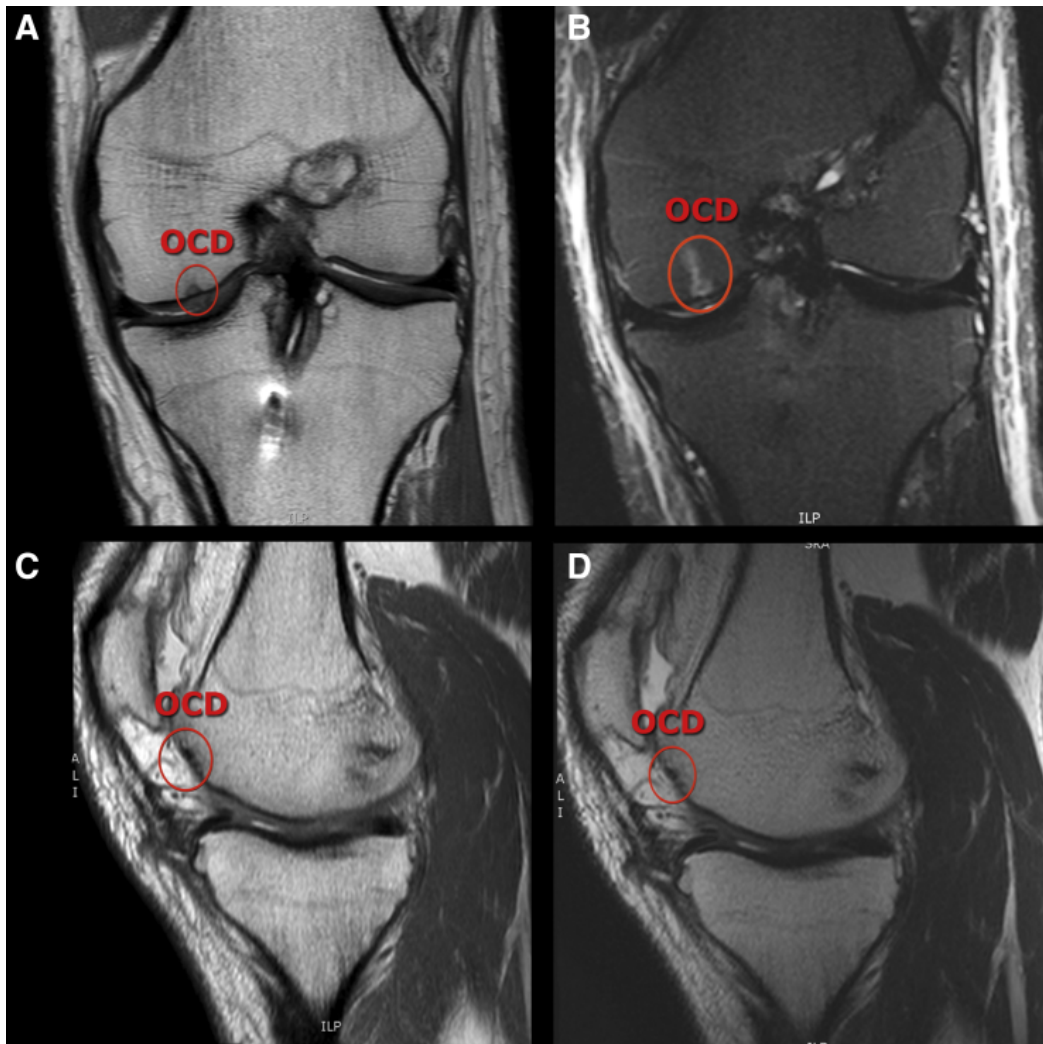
Left knee magnetic resonance imaging (A) An osteochondral defect (OCD) can be seen on a T1-weighted picture in the coronal plane running down the left medial femoral condyle. The same OCD can be seen running along the left medial femoral condyle in T2-weighted images in the coronal plane (B), T1-weighted images in the sagittal plane (C), and T2-weighted images in the sagittal plane (D). (27)
